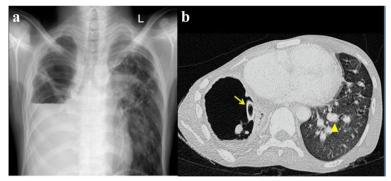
a Chest radiograph (A-P) view showing volume loss on the right side with demarcated air fluid level, loss of broncho-vascular markings above the fluid, and collapsed underlying lung. There is silhouetting of right hilar shadow. Left lung field fibrotic opacities with cavitatory changes. b Contrast-enhanced computed tomography (CECT) chest shows the cicatricial collapse of the right lung with intercostal drainage inside right-sided cavitation with the presence of aspergilloma in the left apical region
